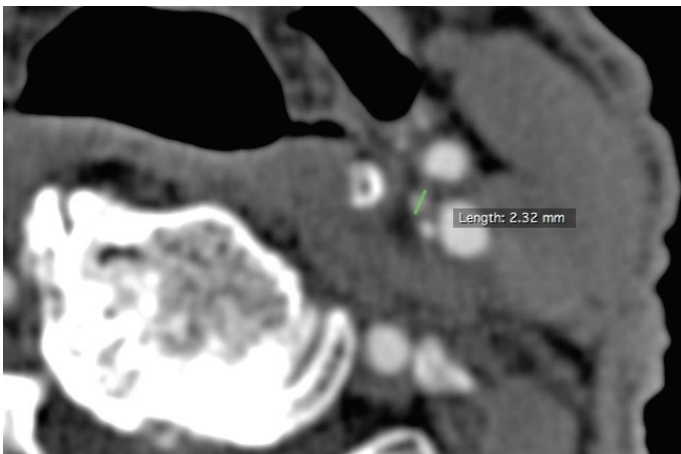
Measurement of CB's longest diameter on axial CT image.
